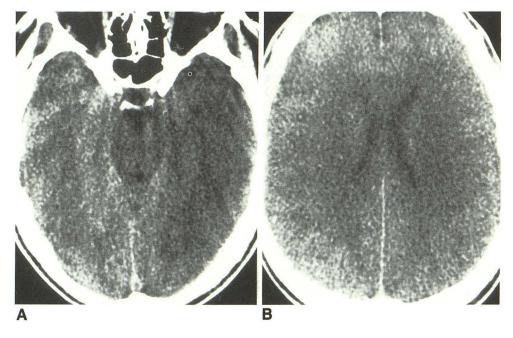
Case 2. Noncontrast CT
